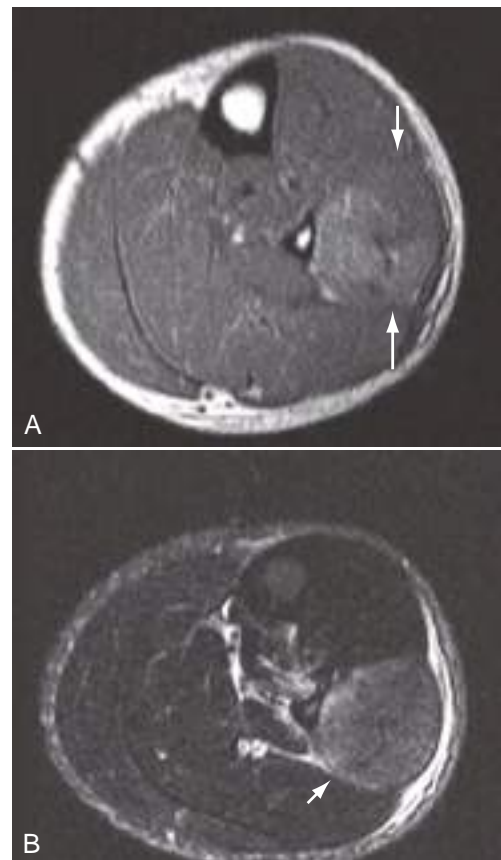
Chronic compartment syndrome. Axial T1-weighted (A) and axial inversion recovery (B) MR images show enlargement of the peroneus longus muscle in the proximal lateral calf (arrows). Note edema signal in B and mildly elevated T1 signal in A suggesting hemorrhage.
